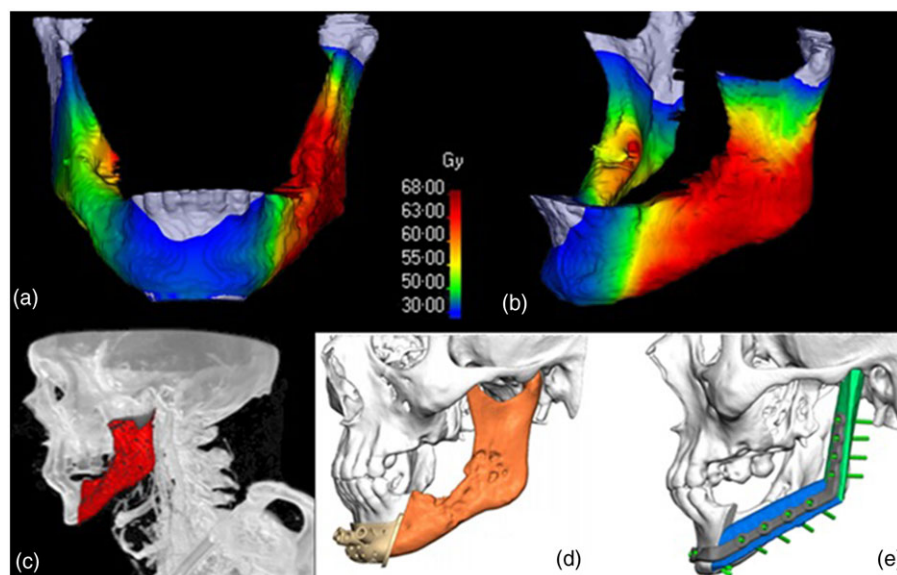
Stages of the dose guided surgery process: delivered radiotherapy dose is deformed onto the mandible surface as defined by the diagnostic CT scan (a) and (b). The isodose line representing high dose and high risk is segmented, displayed in red (c) to guide the surgical design (d) and (e).
